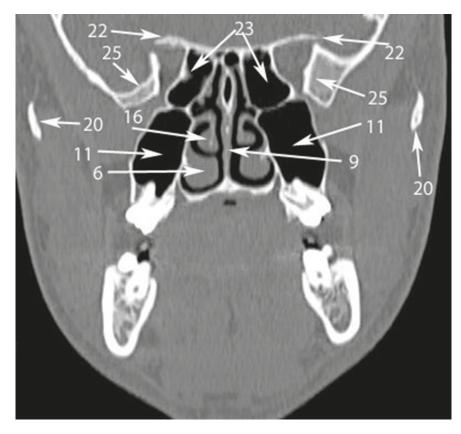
Coronal CT scan at the level of 2nd molars. *Numbers* with *arrows* denote the following anatomical structures: 6 – inferior nasal concha; 9 – perpendicular plate of the ethmoid bone; 11 – maxillary sinus; 16 – middle nasal concha; 20 – temporal process of the zygomatic bone (forms a zygomatic arch together with the zygomatic process of the temporal bone); 23 – sphenoid sinus; 25 – greater wing of the sphenoid bone.
